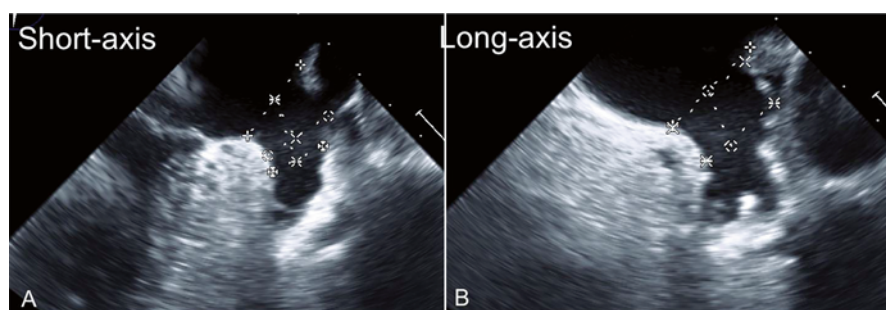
TEE measurements for ACP/Amulet in the short-axis (a) and long-axis (b) views, of both the echocardiographic LAA ostium and the landing zone (10 or 15 mm inside of the ostium for the ACP and Amulet, respectively)
